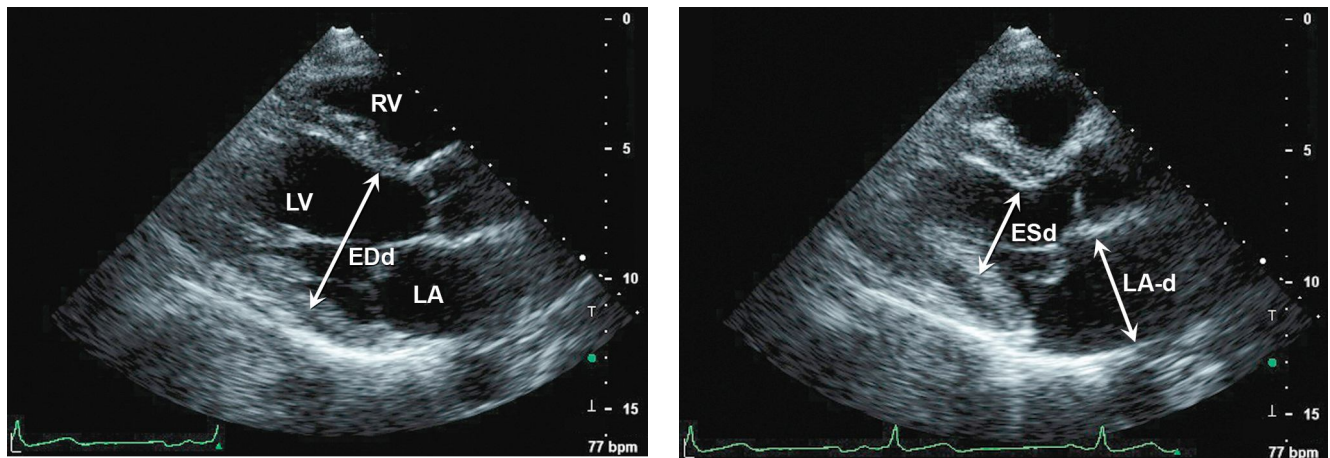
Left ventricular dimensions measured from parasternal long axis and short axis views. Examples of fundamental compared with harmonic imaging.
